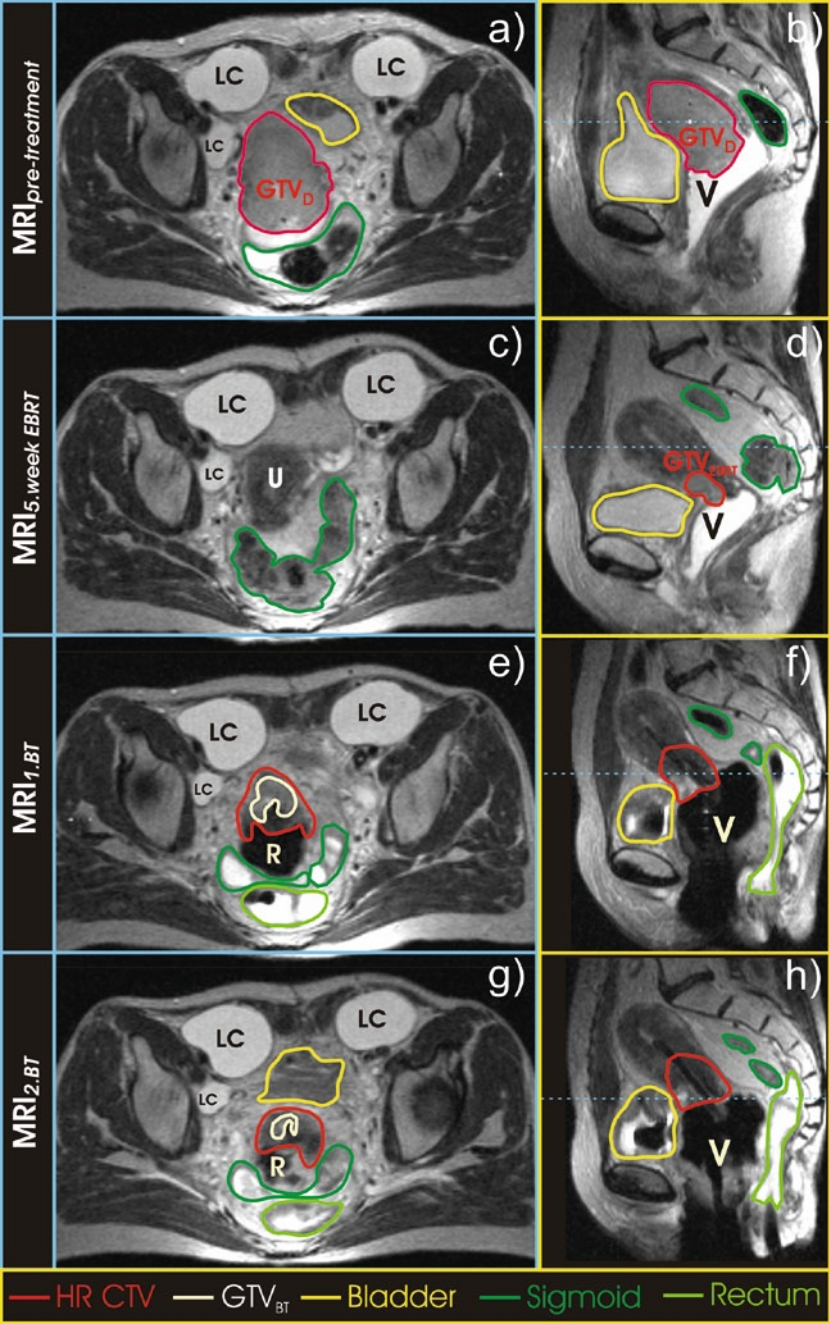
MRI scans of a patient with FIGO IIB cervical cancer at different time points of definitive radiochemotherapy. At diagnosis, a bulky tumor of cervix with proximal infiltration of both parametria is visible (GTV_D) (a, b). Significant tumor regression occurred during external beam radiotherapy (EBRT) and at the fifth week of treatment only small residual tumor of the anterior cervical lip is present (d). The axial scan at the fifth week (c) is taken at the same level, according to bony landmarks, as the pretreatment scan (a). It reveals normal uterine corpus and no evidence of tumor (c, d). At time of first (e, f) and second (g, h) BT further reduction of tumor is seen. *Dotted blue line* on sagittal images represents the level at which the correspondent axial scan was obtained (LC, lymphocyst after laparoscopic lymph node staging; GTV_D, gross tumor volume at diagnosis; V, vagina contrasted with ultrasound gel (b, d) or with packing impregnated with gadolinium (f, h); U, uterine corpus; R, ring)
